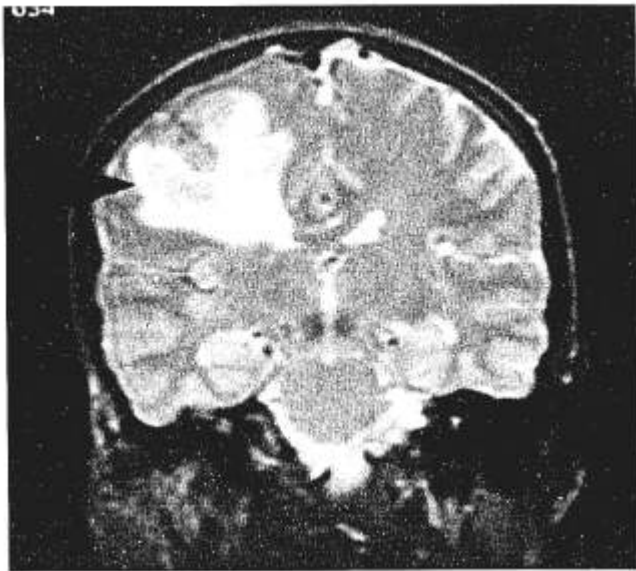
Patient 4. MRI scan showing a right parietal neoplasm with surrounding edema. The patient had increased left-going saccade reaction times which improved after treatment with systemic steroids.
